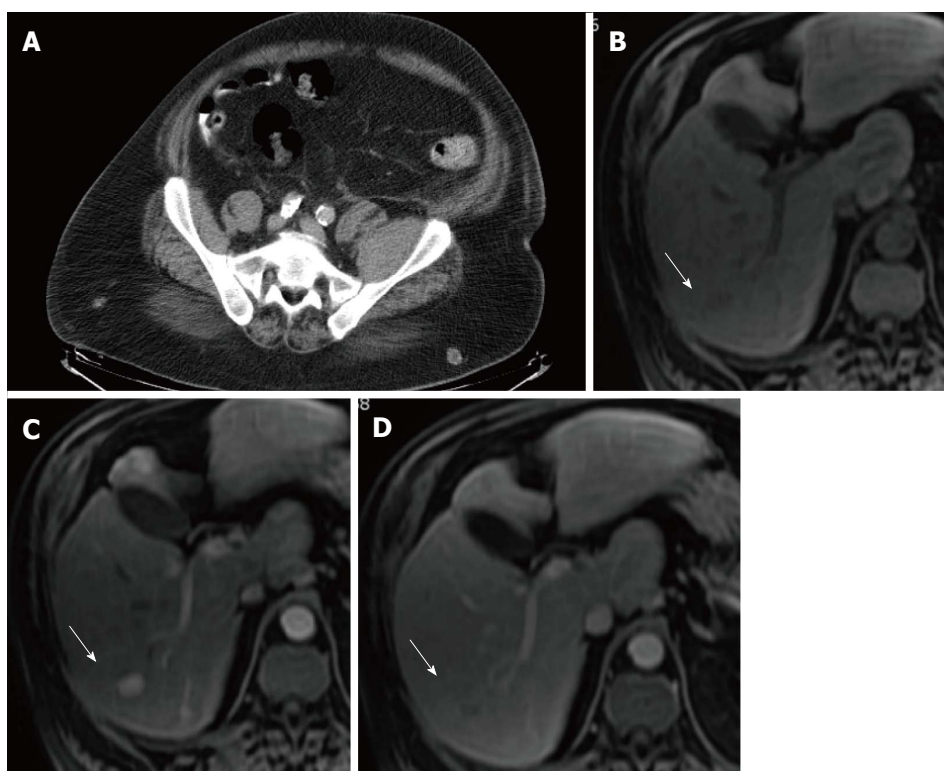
Clinical case 2. A: MDCT showing asymmetry in the psoas-iliac muscles with enlargement of the left iliac muscle; B-D: Dynamic hepatic MRI performed after gadolinium administration. A focal liver lesion with wash in/wash out criteria of hepatocellular carcinoma was depicted in segment VI. MDCT: Multidetector computed tomography; MRI: Magnetic resonance imaging.
